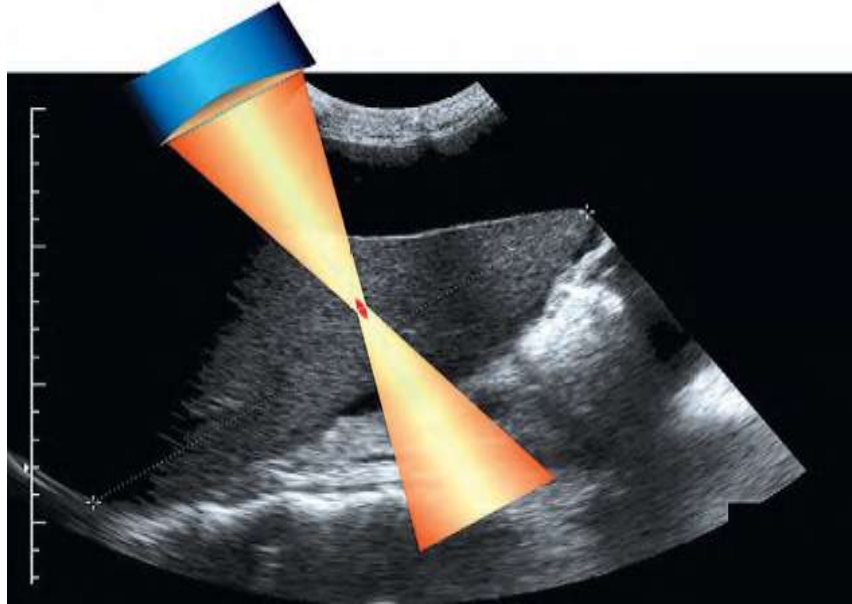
High-intensity focused ultrasound (HIFU).
